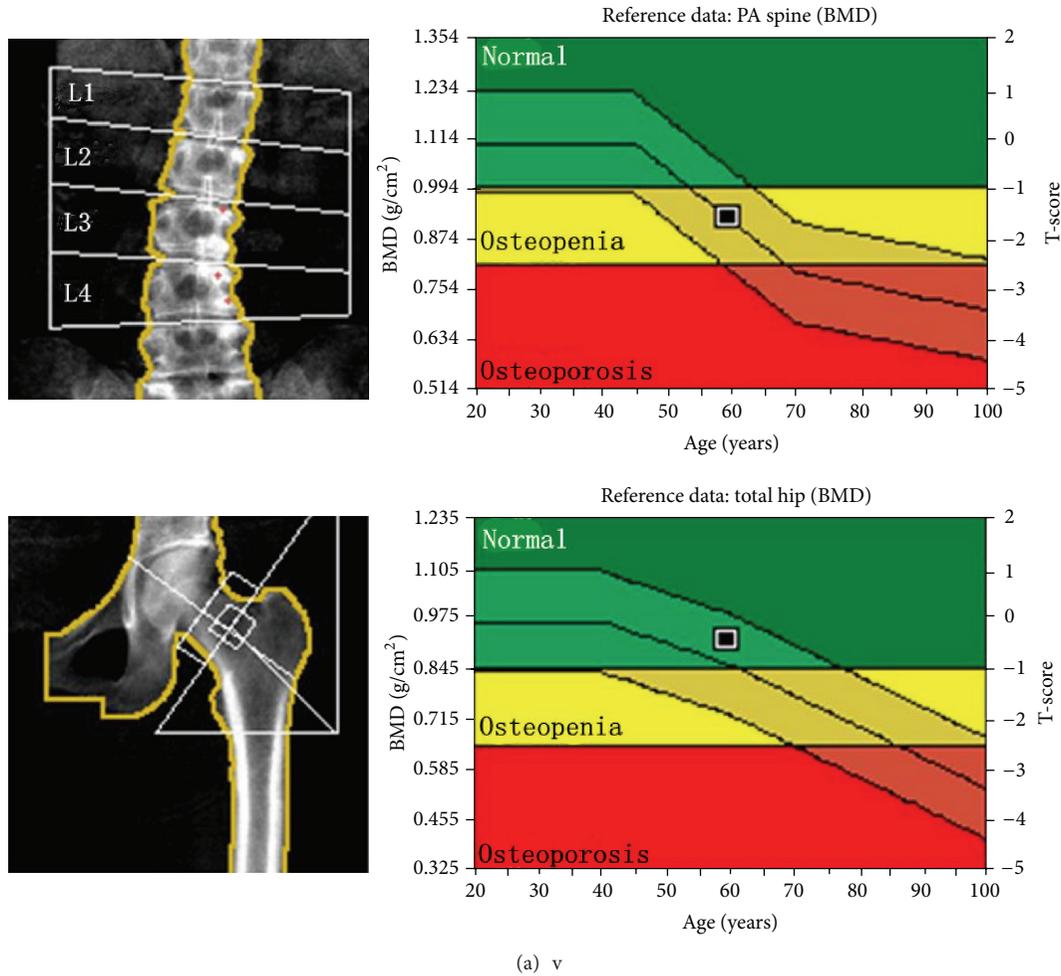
Images obtained from a 59.5-year-old woman who was found by dual X-ray absorptiometry to have osteopenia. (a) The T-scores for lumbar posteroanterior dual X-ray absorptiometry, the femoral neck, and total hip were -1.6 , -0.5 , and -0.4 , respectively. The trabecular bone mineral density of L2–L4 was 71.4 mg/cm^3 , indicating a potential diagnosis of osteoporosis according to the American College of Radiology guidelines. A lateral lumbar radiograph (b) and an axial computed tomography image (c) showed severe osteophytes and end plate sclerosis of the lumbar vertebrae. Focal sclerosis is apparent on the right accessory of L3.
